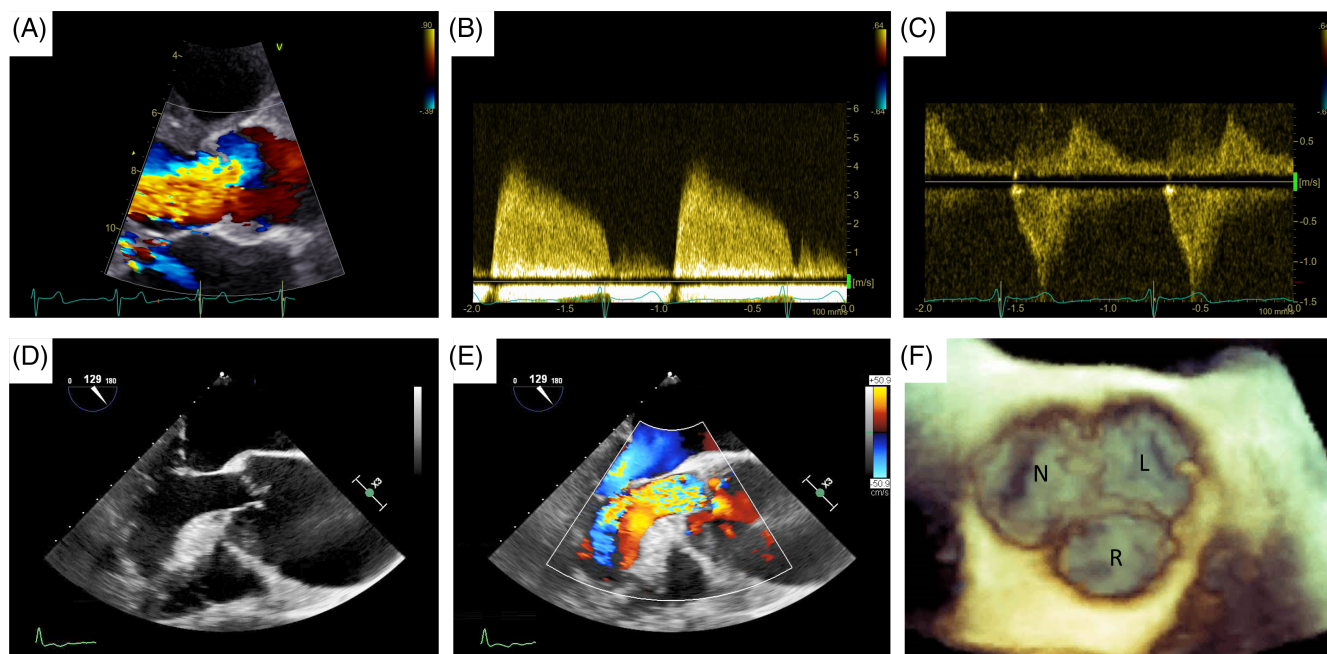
Echocardiographic assessment of aortic regurgitation: (A) TTE colorDoppler focused on left ventricle outflow tract showing a large aortic regurgitant jet, (B) TTE CW Doppler of the regurgitant jet, (C) TTE CW Doppler showing holodiastolic flow reversal in the descending aorta. (D,E) TEE assessment of a patient with severe aortic regurgitation due to a large coaptation defect secondary to aortic root dilatation. (F) 3D TEE assessment of the aortic valve 3D: three dimensional. CW, continuous wave; TTE, transthoracic echocardiography; TEE, transoesophageal echocardiography
